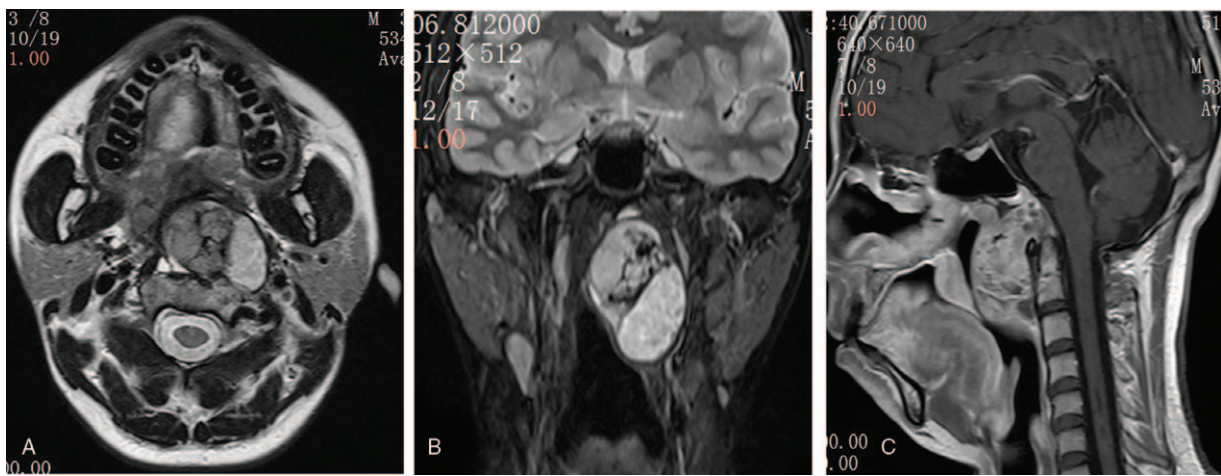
(A, B) Coronal and axial MRI revealed a large inhomogeneous mass causing tracheal dislodgement. (C) Sagittal MRI showed that the clivus was eroded and the left C2–3 intervertebral foramen was enlarged.
